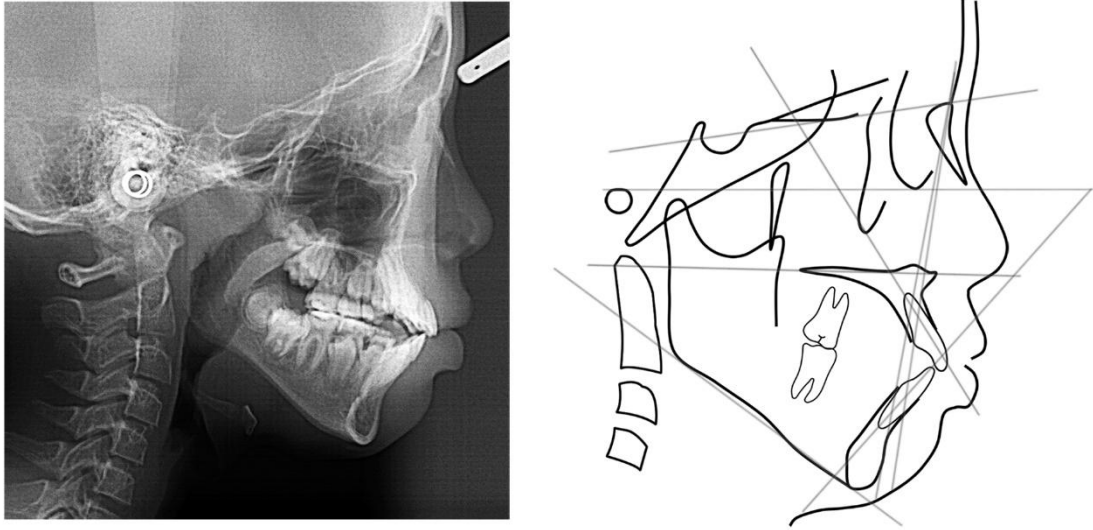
Lateral cephalometric radiographs and tracing after 18 months of FR-4 treatment.
